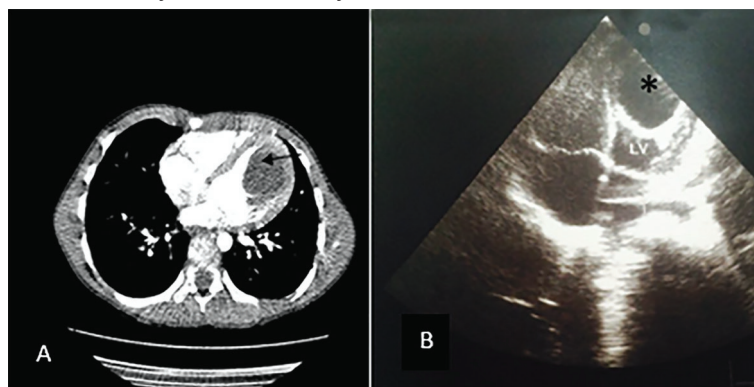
This figure shows cardiac hydatid disease in a seven-year-old boy with abdominal pain. Abdominal ultrasonography revealed several cysts with internal membranes in the liver resembling hydatid cysts. Similar cysts were also detected in the heart from the subxiphoid view. A. Axial contrast-enhanced CT scan of the chest shows a well-defined unilocular intraventricular cyst located at the left ventricular apex (arrow) with no involvement of any other organs including the lungs. The cyst has a low density (10 HU), which is compatible with a simple cyst. B. Echocardiography reveals a well-defined anechoic cyst (asterisk) with posterior acoustic enhancement within the left ventricular apex in the four-chamber view. During hospitalization, the patient experienced dyspnea and chest pain, and finally underwent open thoracic surgery for cardiac hydatid cyst excision, but unfortunately expired due to cyst rupture and anaphylactic shock. This figure was obtained from a patient admitted to the authors' institution and was not previously reported elsewhere.
